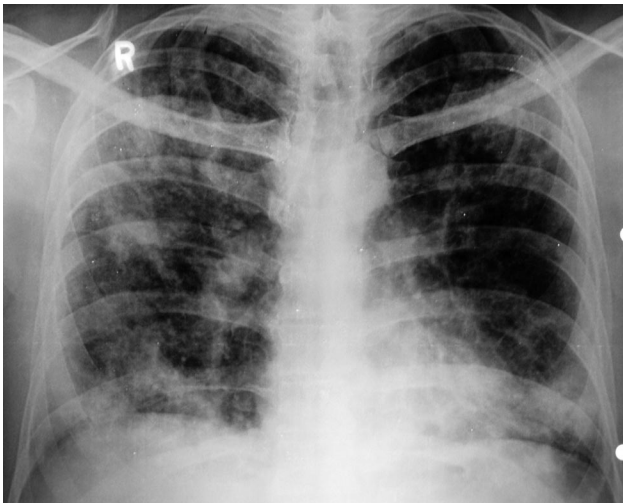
Chest radiograph shows bilateral reticulonodular opacities.
